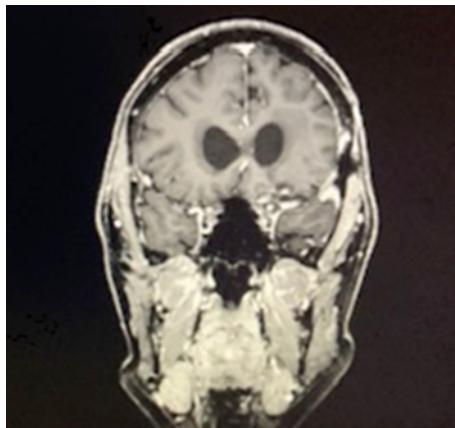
MRI, before surgery, a sphenoid wing meningioma in the coronar plane T1-weighted imagine after contrast administration. The midline medially displaced and compression of the left lateral ventricle.
